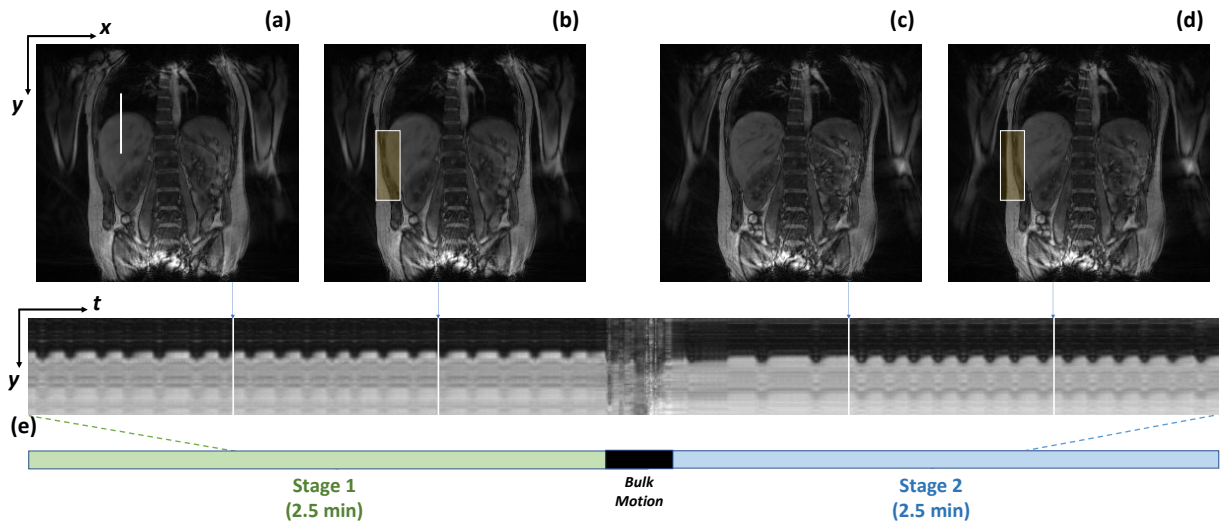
Dynamic MR images reconstructed by the proposed method. The real-time profile (e) is plotted for a part of the experiment where the bulk motion happens, and two representative images (a) & (b) and (c) & (d) are shown for each body position. The white line in (a) shows where the time profile was taken. A yellow box at the edge of the patient has been drawn for the first body position (b) and the same box was also drawn for the second body position (d) at the same coordinates (regarding the image). One can clearly see that the body of the subject moved to the right of the image during the bulk motion, and that the proposed method managed to catch that motion.
